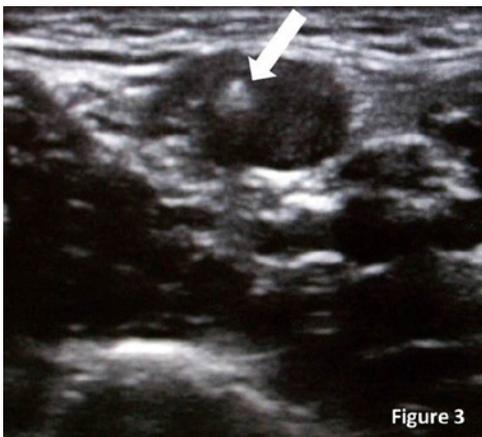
Ultrasound image of an out-of-plane technique with visualization of the needle and cannula (arrow) entering the vessel.
